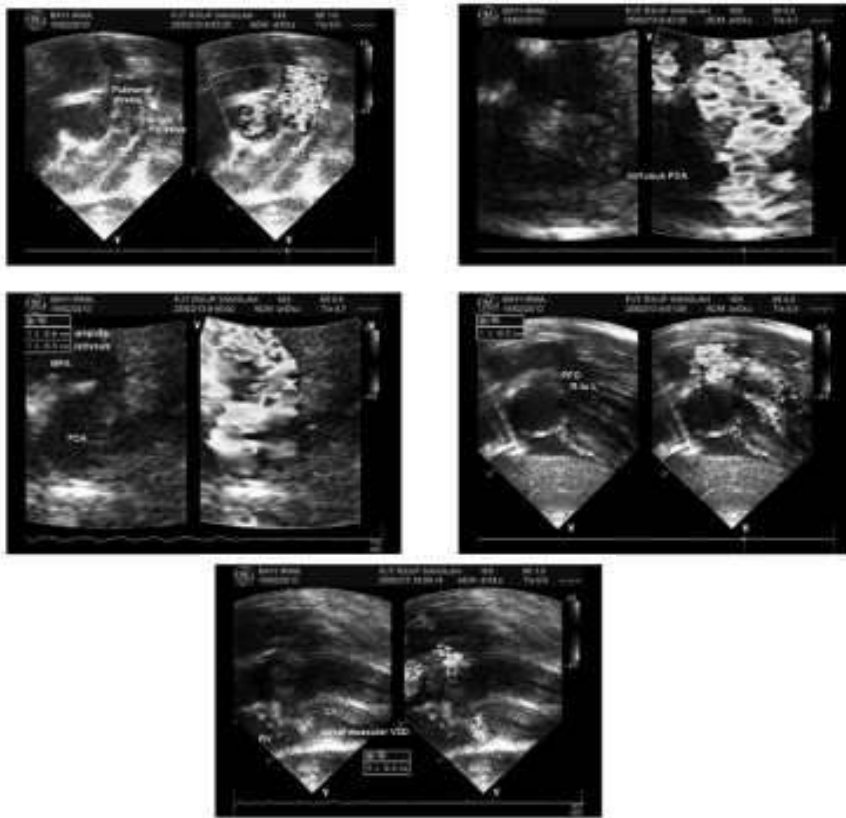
Echocardiography results.
